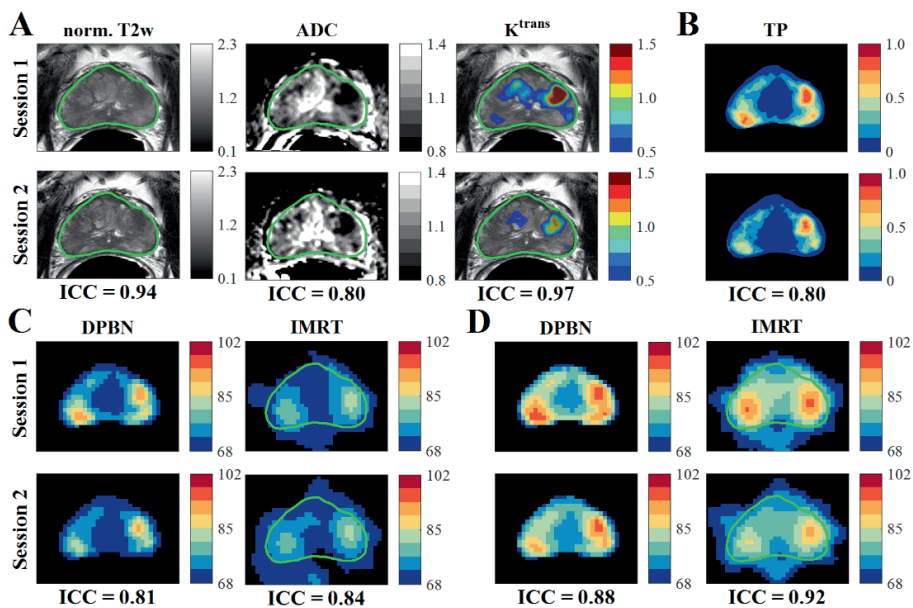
Example of an axial slice through the prostate. In each panel A-D the first (top row) and second planning session (bottom row) are compared. The ICC value is shown for each set of maps. Panel A depicts the mp-MRI: normalized T2w, ADC (in $10^{-3} \text{ mm}^2/\text{s}$) and K^{trans} map (in min^{-1}), where K^{trans} is shown as a colorwash on top of the normalized T2w scan. The DPbN map (in Gy) and IMRT plan (in Gy) are shown for linear (panel C) and square root (panel D) dose mapping functions. The delineated prostate is contoured in green.
